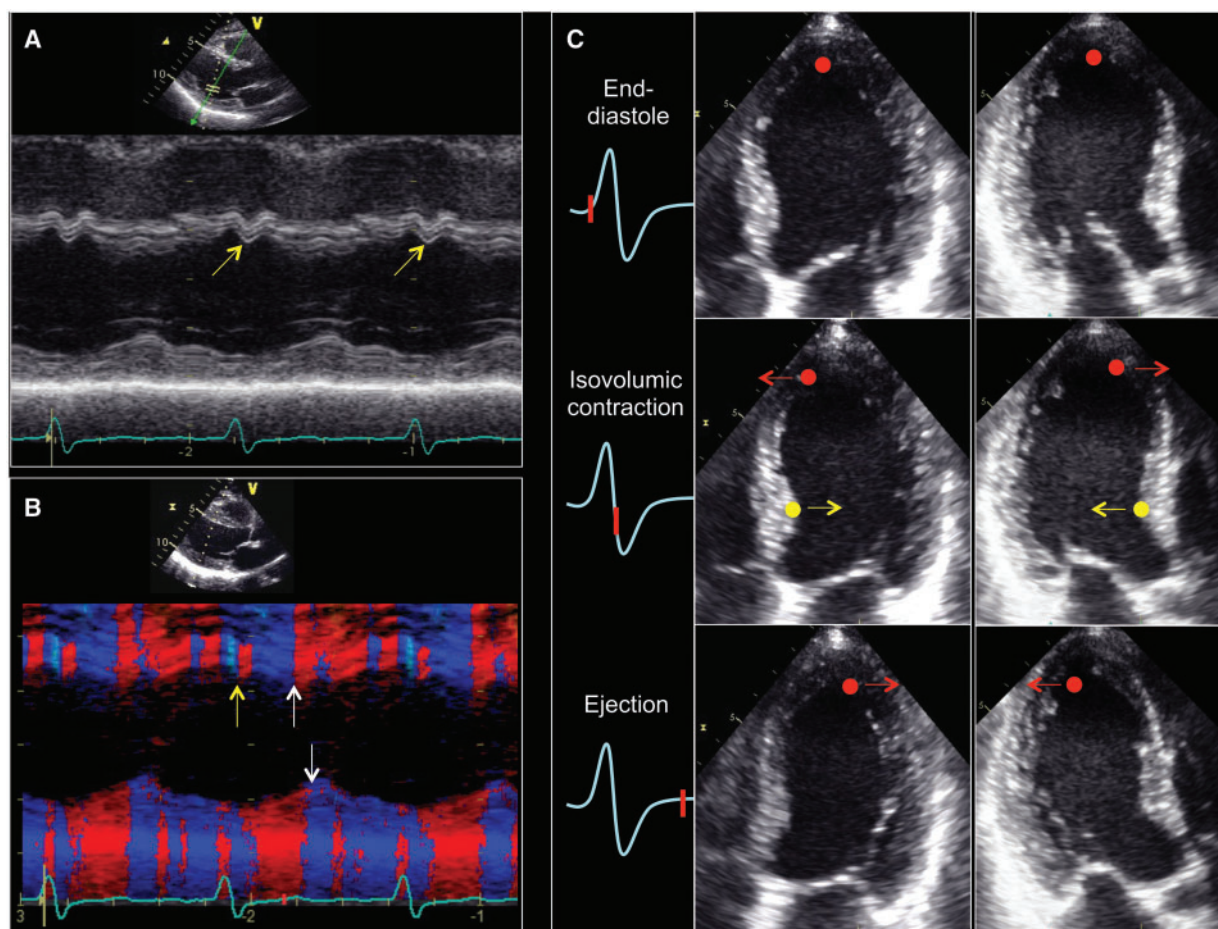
Typical echocardiographic patterns of abnormal left ventricular contraction termed 'septal beak' (or 'septal flash') and 'apical rocking' in patients with complete left bundle branch block. (A) M-mode tracing of the LV obtained from parasternal long-axis view demonstrating rapid short inward motion of the IVS before ejection (yellow arrows) followed by the stretching (outward motion) of the IVS with subsequent full contraction. (B) TDI M-mode tracing of the LV showing the changes in the direction of IVS movement (towards or away from the transducer) at different time intervals of cardiac cycle in a patient with LBBB, which can be easily tracked with the change of colour pattern. A short blue part and the next short red part during isovolumic contraction (yellow arrow) represent the early rapid movement of the IVS (septal flash); due to non-simultaneous electrical activation of the septum and lateral walls, they reach the peak of contraction at different time points (white arrows). (C) The sequence of mechanical events in patients with LBBB resulting in a typical septal-to-lateral apex motion pattern termed 'apical rocking'. An early electrical activation of the IVS causes its short contraction (yellow arrows) resulting in the medial apex moving (red arrows in the middle panels). Then, the delayed activation of the lateral wall pulls the apex laterally during the ejection phase while stretching the septum (red arrows in the bottom panels). IVS, interventricular septum; LBBB, left bundle branch block; LV, left ventricle; TDI, tissue Doppler imaging.
